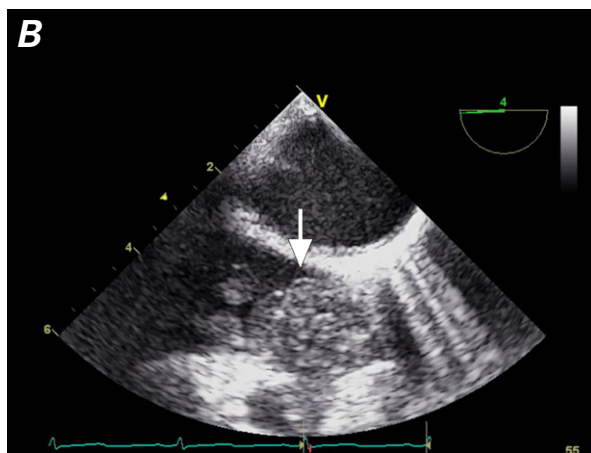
Transesophageal echocardiograms show an echodense structure A) at the root (arrow) of the pulmonary trunk and B) in the right ventricular outflow tract (arrow).
